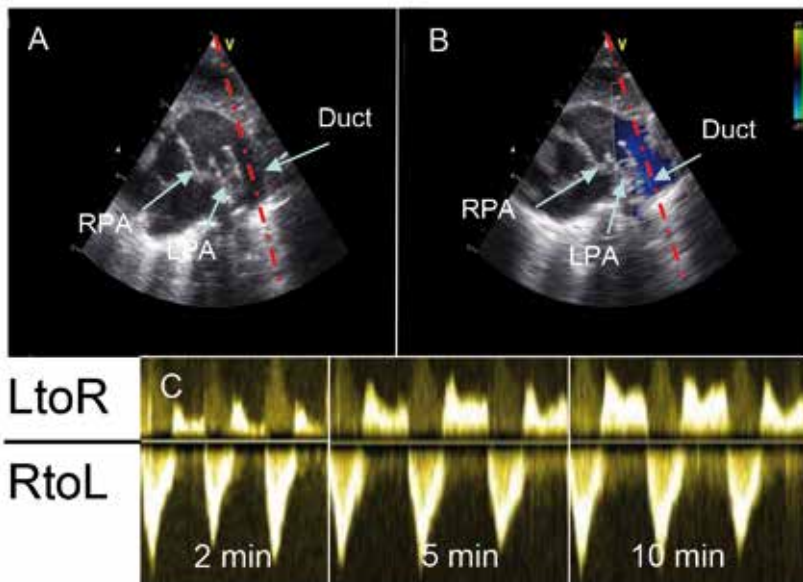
Examples of DA blood flow collected using continuous wave Doppler imaging (A and B) showing the left pulmonary artery LPA, right pulmonary artery (RPA) and ductus arteriosus (DA) marked with arrows. (C) DA shunt at 2 minutes, 5 minutes and 10 minutes after birth.
